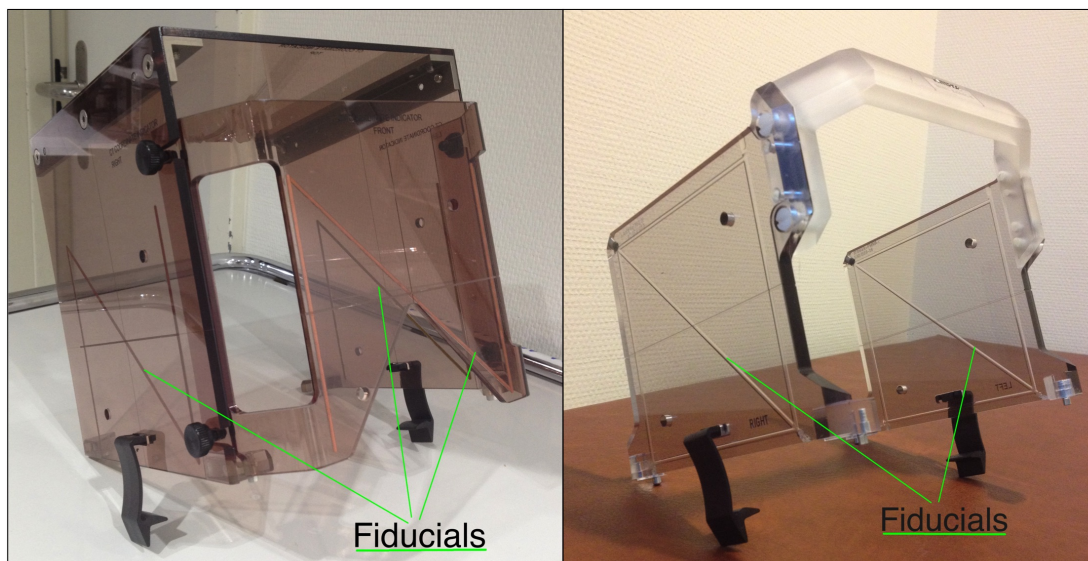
The Indicator Boxes used for acquiring the therapeutic images (Leksell Gamma Knife Perfexion[®], Elekta Instruments, AB, Sweden) : CT (left) MRI (right).
